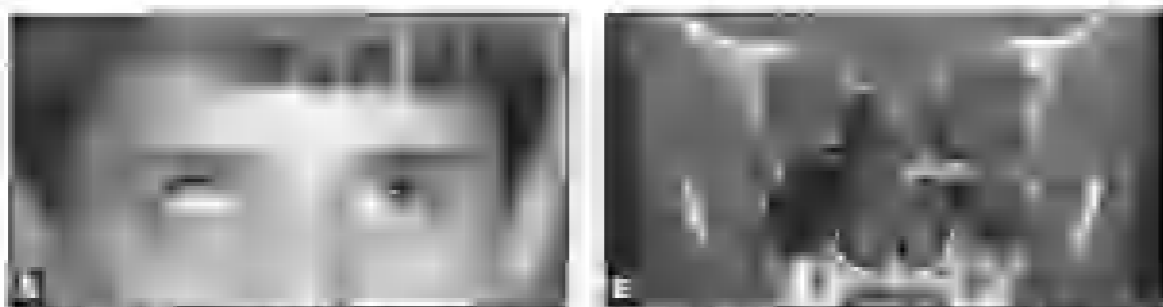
(A) An external view of a positive orbital fracture. Note the patient's inability to elevate the left eye vertically if trying to look up. (B) A computed tomography scan (sagittal view) showing the orbital fracture (arrow) with the fracture of the inferior rectus.
